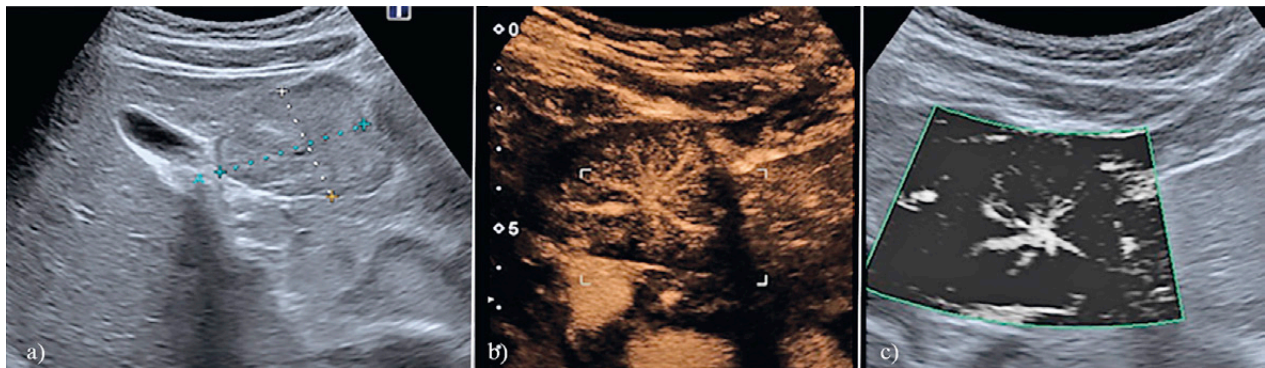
A 55-year-old asymptomatic woman with incidental focal liver lesion of 4 cm FNH on conventional ultrasound (a). CEUS with arterial spoke-wheel sign (b). SMI with typical spoke-wheel pattern (c).
